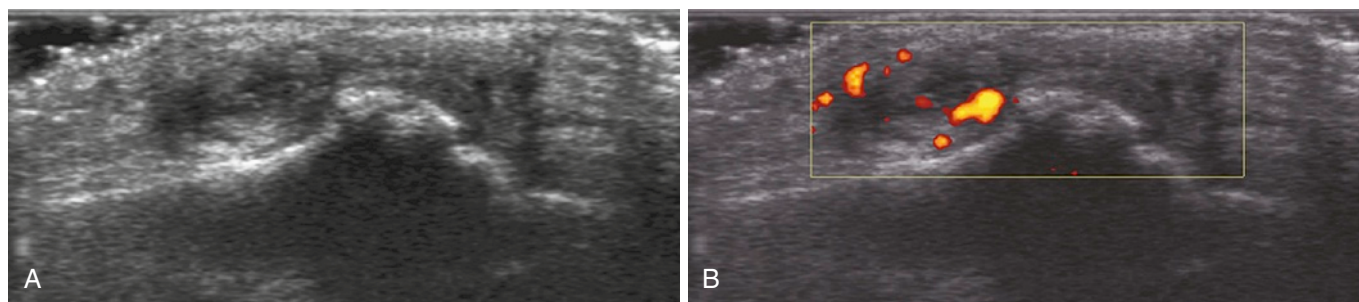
Synovitis in the second metacarpophalangeal joint is identified on the dorsal longitudinal view. A, Synovial thickening on gray-scale ultrasonography. B, Doppler signal in the thickened synovium.
